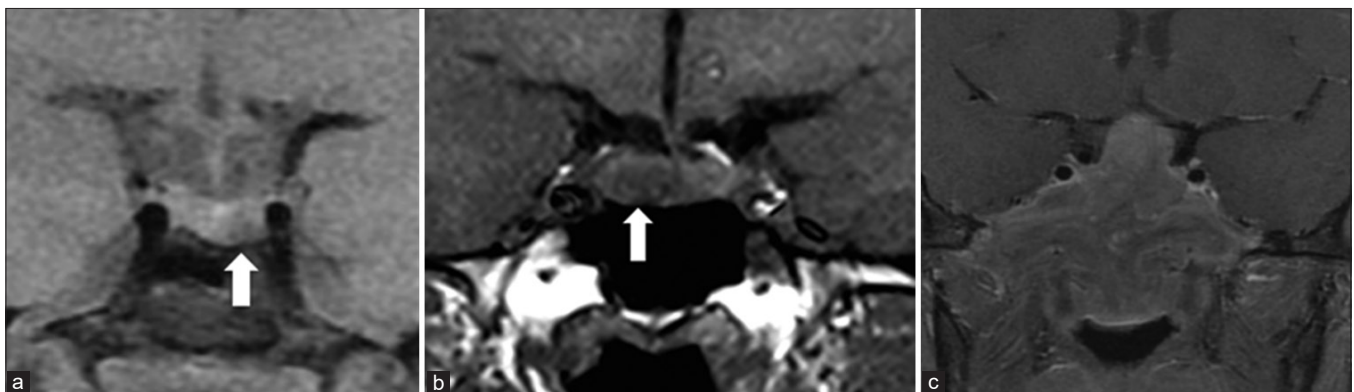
MRI coronal sections of the pituitary without contrast demonstrating the three different categories of prolactinomas. (a) Microprolactinoma: A small (6 × 6 mm) hypointense lesion within the left pituitary gland associated with mild depression of the sellar floor in keeping with pituitary microadenoma. The pituitary stalk is located in the midline and the suprasellar optic pathway is unremarkable. (b) Macroprolactinoma: A small (1.1 × 0.9 cm) hypointense lesion within the right pituitary gland in keeping with pituitary macroadenoma. The pituitary stalk is deviated to the left side. (c) Giant invasive prolactinoma with suprasellar extension and compression and upward displacement defect over the optic chiasm. The stalk could not be identified
